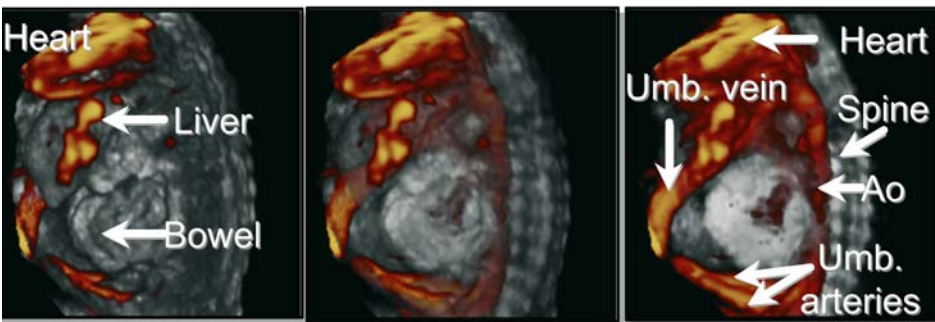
Longitudinal view of thorax and upper abdomen. Three-dimensional power Doppler rendering allows visualization of all vessels described in Fig. 7.1 and their relationship to one another
